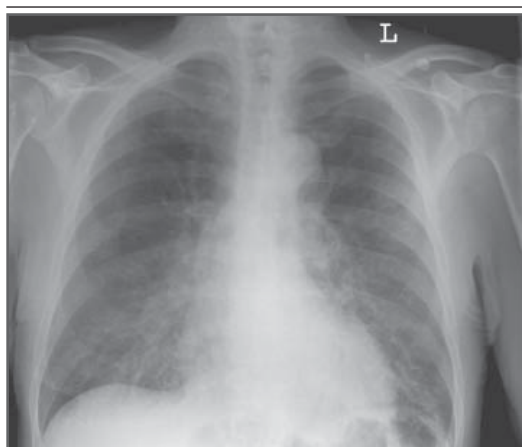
Anteroposterior Radiograph of the Chest, Demonstrating Interstitial Pulmonary Edema and Borderline Cardiomegaly.
